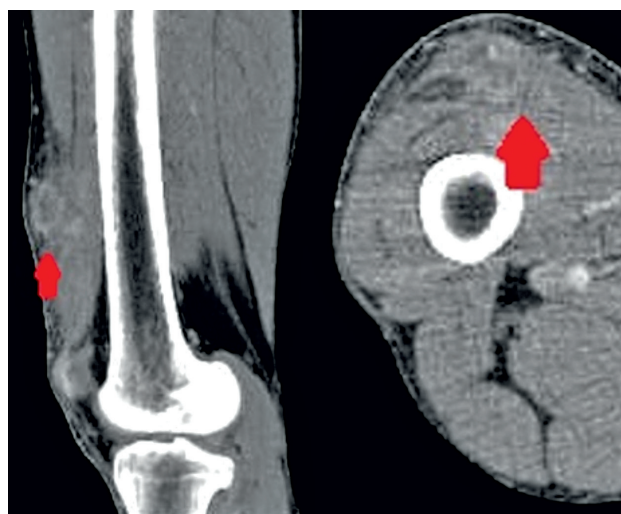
CONTRAST-ENHANCED CT OF THE THIGH DEMONSTRATING A MULTILOCULAR SUBCUTANEOUS AND INTRAMUSCULAR INFLAMMATORY COLLECTION INVOLVING THE VASTUS LATERALIS MUSCLE ($66 \times 33 \times 35$ MM), INDICATED BY RED ARROWS, SHOWN IN SAGITTAL AND AXIAL SECTIONS
